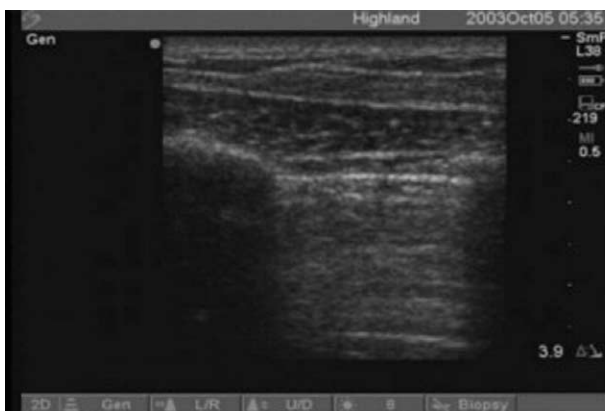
(a) 2D ultrasound (positive for pneumothorax): bedside ultrasound demonstrating the absence of comet tailing and sliding (see video). (b) M mode ultrasound (positive for pneumothorax). Below the pleural line there are a series of wavy horizontal lines commonly seen with lack of movement or in this case when movement is not seen because there is air in the pleural space.
